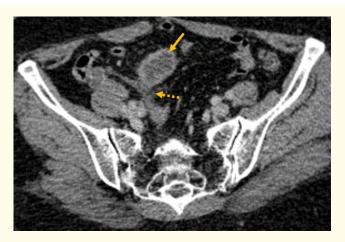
Initial CT scan: Axial contrast-enhanced CT scan in the portal phase showing an intraperitoneal mass (arrow) with central necrosis in contact with the terminal ileal loop (dashed arrow), without signs of invasion.
